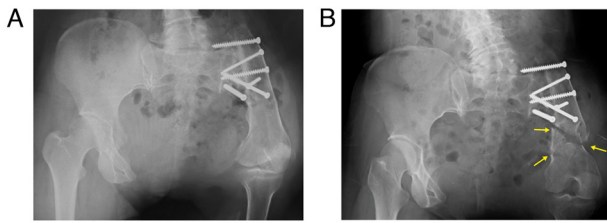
Preoperative radiographs. (A) A radiograph 28 years after hip rotationplasty before injury. (B) Radiograph showing comminuted fractures of distally reconstructed bone (arrows).
